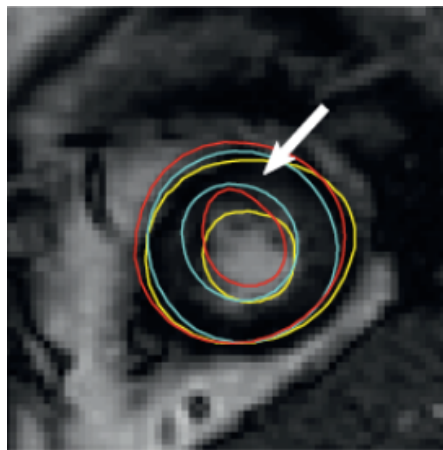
Left ventricle geometry segmentation from magnetic resonance images. Endocardium and epicardium contours marked by different expert raters. (Adapted from Suinesiaputra et al. (2014))
